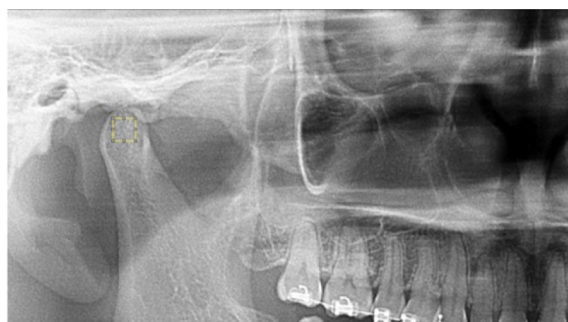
ROI 60 × 60 pixels (yellow square) of the right mandibular condyle on the cropped panoramic radiograph.
